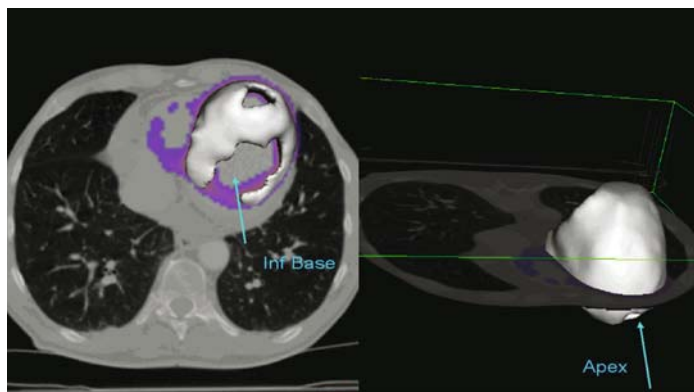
An example of a cardiac fusion display combining the iso-surface derived from one modality ( $^{18}\text{F}$ -FDG PET scan demonstrating infarction), with co-registered slice images from another modality (Electron Beam Computed Tomography).
